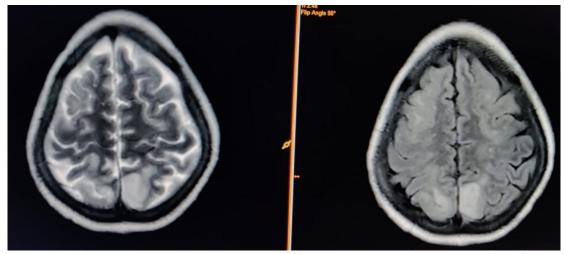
Axial T2-WI and FLAIR images showing multiple focal area of T2/FLAIR hyperintensities noted in bilateral high parietal lobes, bilateral centrum semiovale, bilateral corona radiata, right internal capsule, left putamen, bilateral white matter cerebral hemispheres and splenium of corpus callosum- Holohemispheric watershed pattern-Atypical PRES
